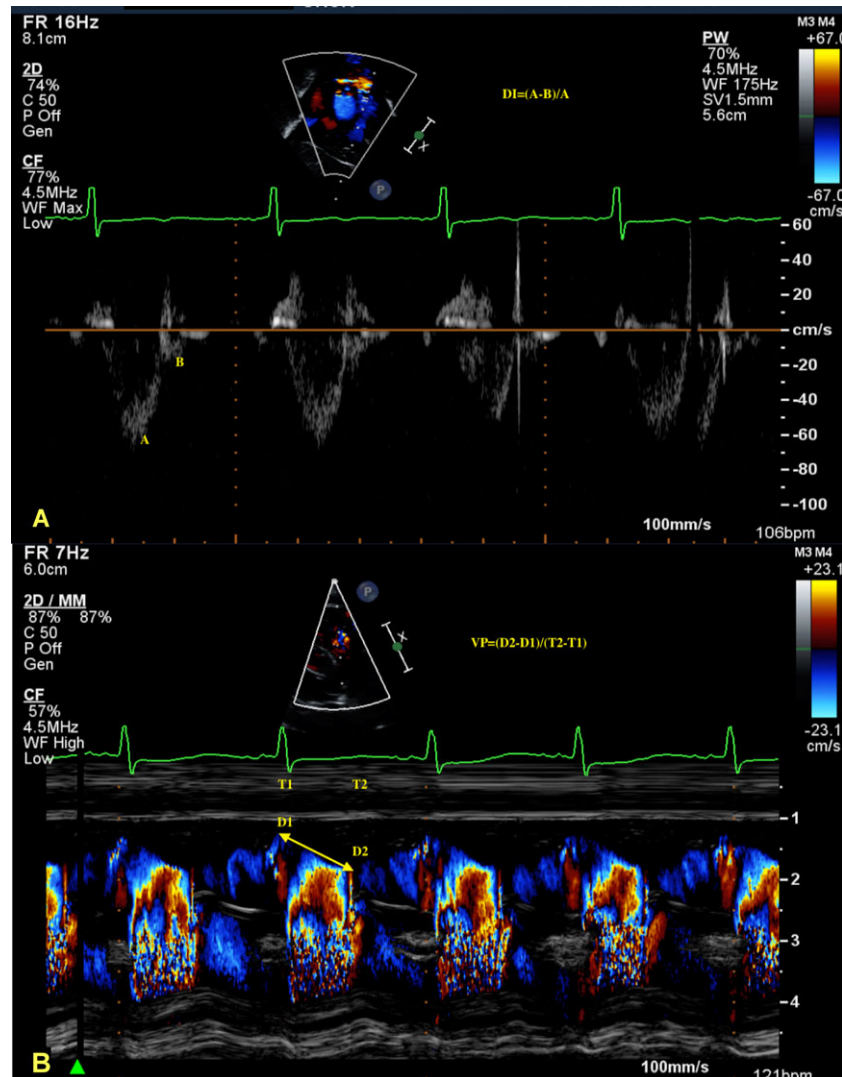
Echocardiography images showing the assessment of deceleration index and velocity propagation. A. Deceleration index, which is the ratio of the difference between inflection flow and peak flow to the peak flow. B. Velocity propagation, which is the ratio of the difference between two distances to the difference between the 2 time points.
